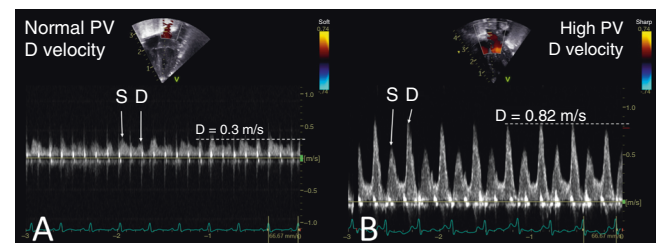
Pulmonary Vein Flow and Patent Ductus Arteriosus. Comparison of pulmonary vein Doppler patterns between preterm infants with no transductal shunt (a) vs those with a hemodynamically significant ductus arteriosus (b). S, systolic wave; D, diastolic wave.
